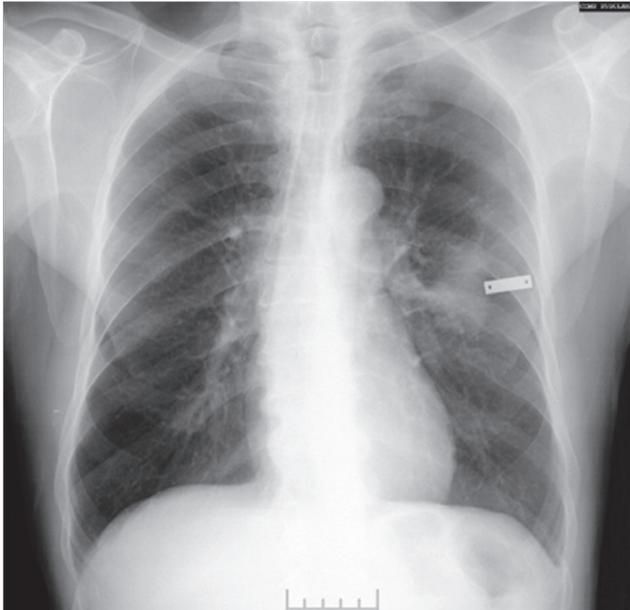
Posteroanterior chest X-ray
